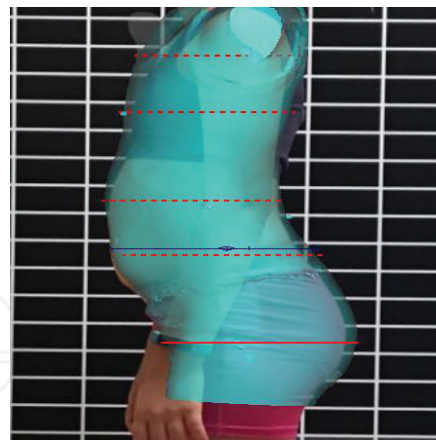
New digital imaging can be used to match clinical photos and digital X-rays to patient-specific morphology.
